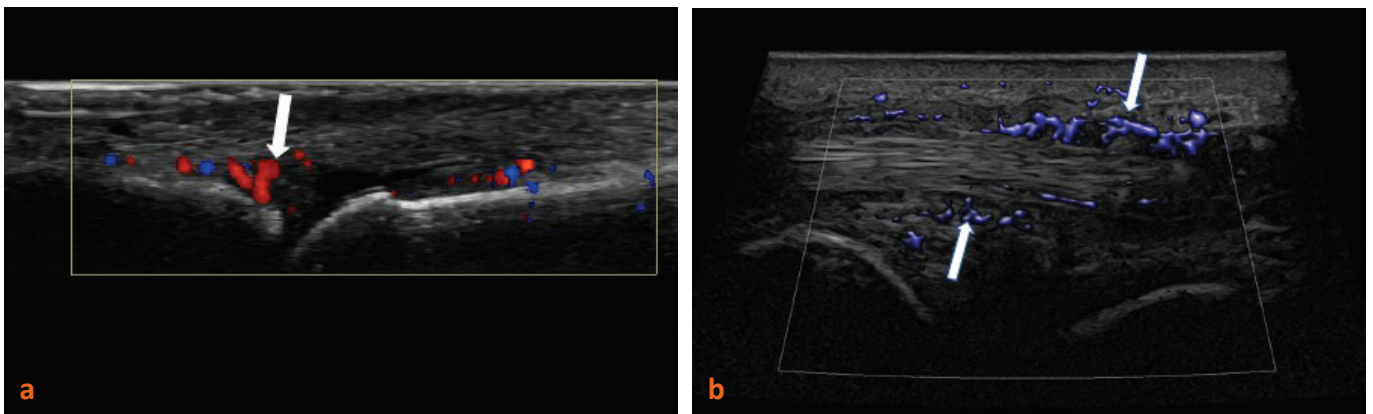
US findings in RA. (a) MCP joint in a patient with RA. Joint effusion and active synovitis: positive Doppler signal (white arrow) without soft tissue swelling. (b) Longitudinal scan of the Extensor Carpi Ulnaris (ECU) tendon in a patient with RA. Signs of active tenosynovitis with thickened synovium and vascularity in the flow imaging technique (white arrows).
